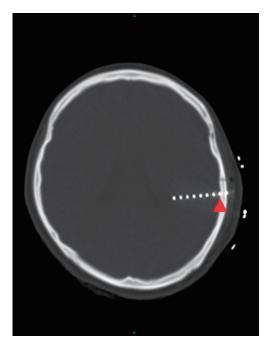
CT scan showing the retained depth electrode, suggesting that the eighth contact from the tip was caught in the internal table of the skull (arrowhead).
